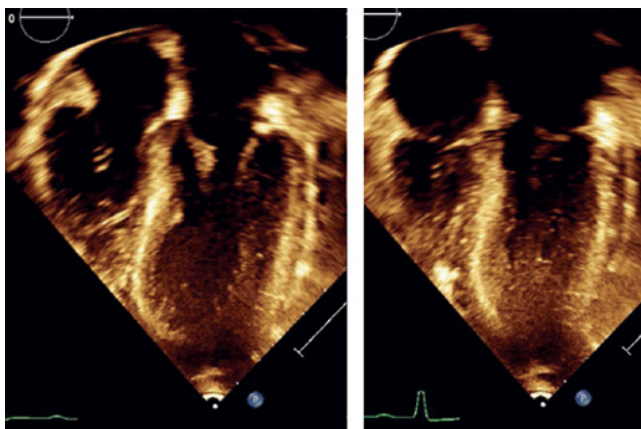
Transthoracic echocardiogram of hypertrophic cardiomyopathy. Both images are subcostal four-chamber views demonstrating a very thickened left ventricular free wall and interventricular septum, which causes left ventricular outflow tract obstruction. Source: Reproduced from Lee et al [98] with permission of Wolters Kluwer.
